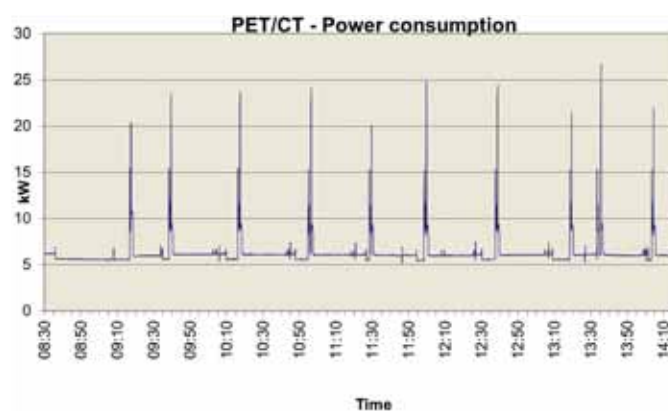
PET/CT Electrical power as a function of time
